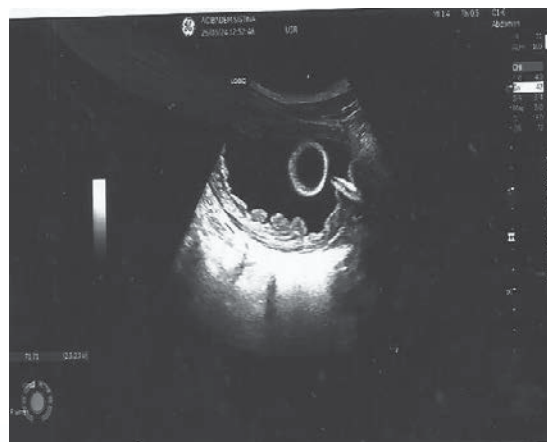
Ultrasound findings of the bladder in a 27-year-old patient with atonic bladder following spinal cord injury
